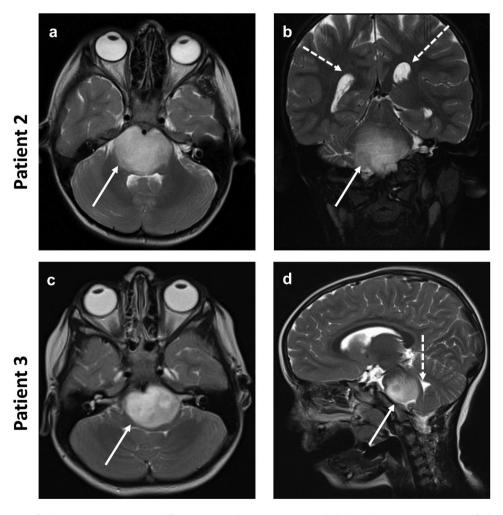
MRI scan of the brain showing a diffuse pontine lesion. (a) - Axial T2WI, (b) - Coronal scan of the brain showing a hyperintense, solitary diffuse lesion of the pons of patient 2 (solid arrow). Dotted arrows indicate mild dilatation of the lateral ventricles. (c) – Axial (d) – Sagittal T2WI scan of the brain showing a pontine glioma infiltrating the pons (solid arrow) and compressing the fourth ventricle (dotted arrow).
